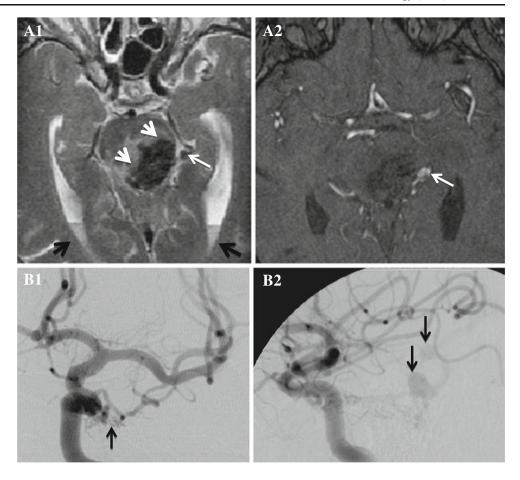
MRI performed at 1.5 T (A) and DSA (B) of a 72-year-old male with an infratentorial ICH due to a dural arteriovenous fistula (dAVF). T2-weighted imaging (AI) shows the pontine ICH (white arrowheads) and the associated IVH (fat black arrows). Furthermore, a venous dilatation associated with the dAVF can be depicted on T2w (A1) and TOF-MRA (A2) (thin white arrow). DSA with selective catheterization of the left internal carotid artery in anterioposterior (B1) and lateral (B2) view confirms the arteriovenous shunt with the venous dilatations (thin black arrows)
